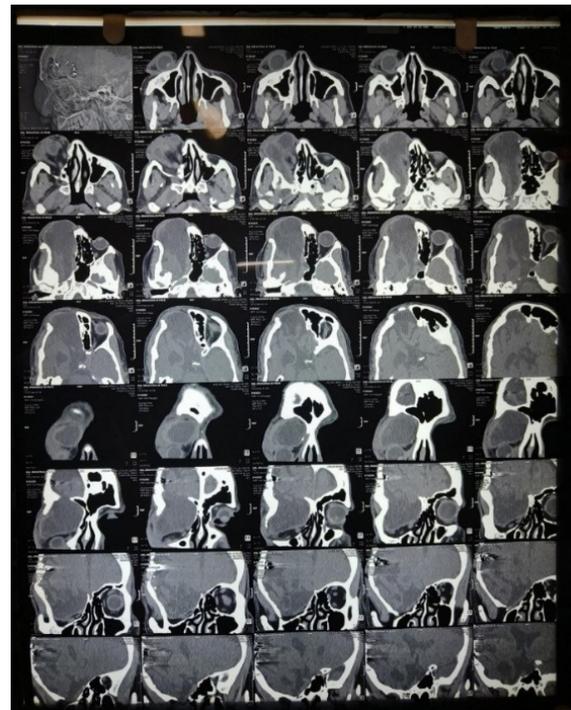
Coronal section CT Head and orbit at the level of paranasal sinuses representing significant proptosis R eye
